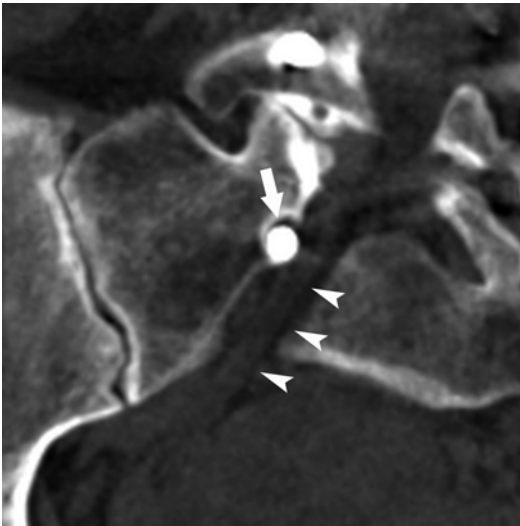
Radicular pain after lumbar arthrodesis. CT oblique reformat demonstrates low and medial position of S1 screw (*arrow*) that displaces S1 root (*arrowheads*)
